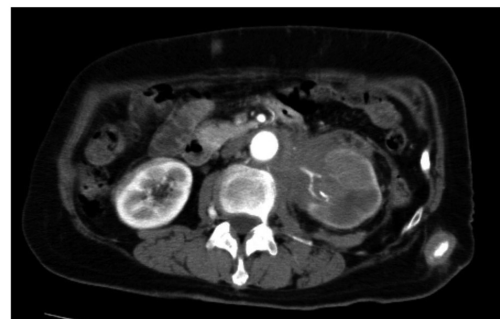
Computed tomography showed a mass around the left renal hilum and subcutaneous abdominal masses.
